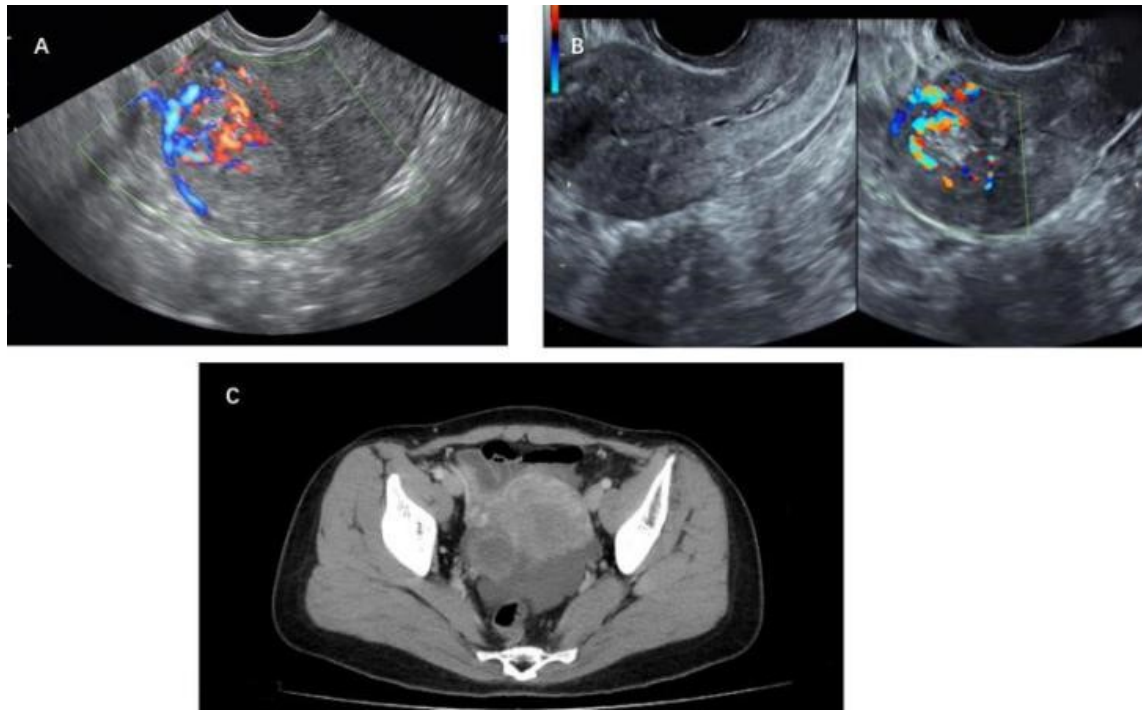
The ultrasound and Computed tomography scan images. (A) The first ultrasound scan taken in our hospital. A mixed echogenic mass measuring about $1.9 \times 1.9 \times 2.0$ cm in size was embedded in the myometrium of the right posterior uterine wall near the fundus. Color-flow Doppler analysis revealed high blood flow at the periphery of the mass, making it difficult to determine the boundary between the myometrium and the endometrial cavity. (B) Transvaginal ultrasound image after one month of MTX therapy. A $1.9 \times 1.9 \times 2.0$ cm mixed echogenic mass with mild hypervascularity was found near the right cornu and showed no boundary to the myometrium. The endometrium was 15 mm thick and not continuous. (C) The CT scan showed a 2.5×2.5 cm abnormal mass within the right posterior uterine wall and with an obscure boundary.
